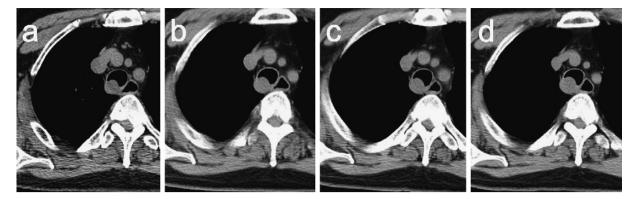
Time series of chest CT: (a) first admission; (b) 1 year later; (c) 2 years later; (d) 3 years later.
